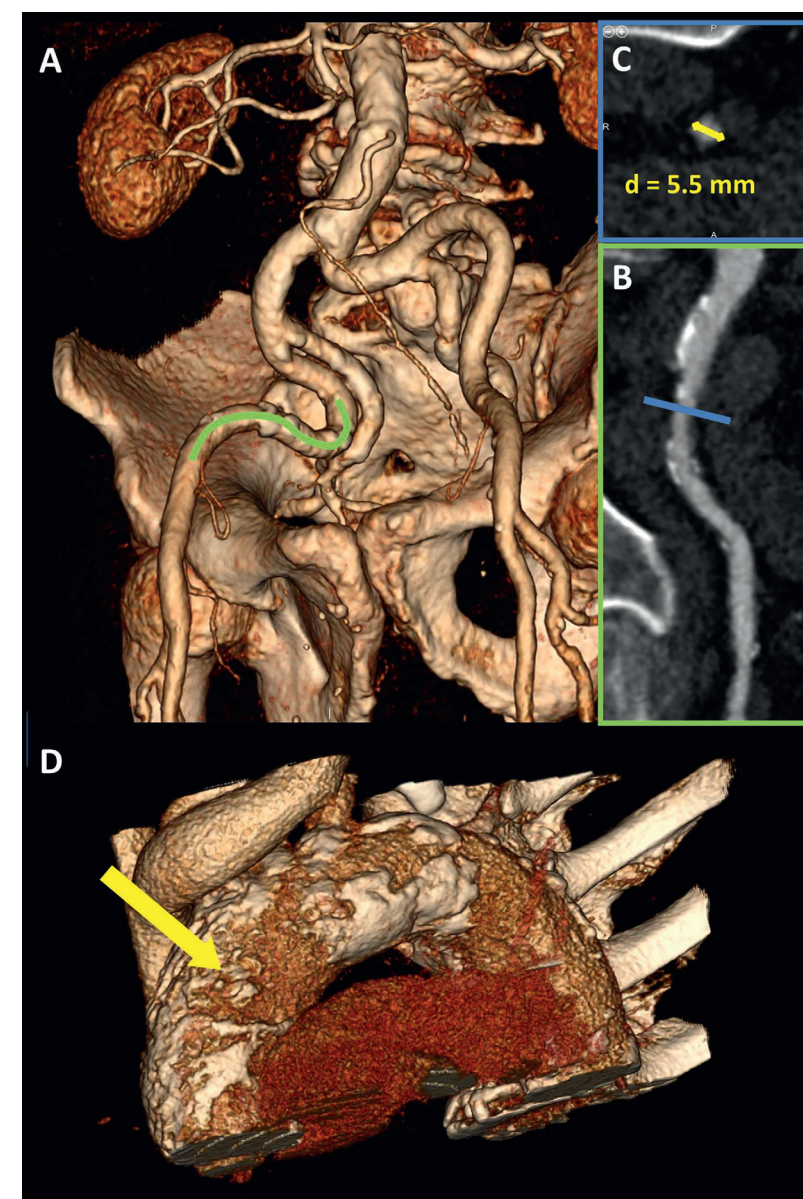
Assessment of TAVR access with multidetector row computed tomography (MDCT). (A) Severely tortuous iliofemoral arteries visualized with 3D volume rendering. (B) Segment of the right external iliac artery (green line) was more closely studied in a multiplanar reconstruction plane outlining high atherosclerotic burden with multiple plaques. (C) The cross-sectional lumen of the narrowest part of the vessel (blue line) was assessed. The smallest diameter was 5.5 mm (yellow arrow), precluding a safe transfemoral approach for the transcatheter aortic valve replacement (TAVR). (D) Severely calcified thoracic aorta – porcelain aorta particularly in the anterolateral portion of the ascending aorta, corresponding to the landing zone for transaortic approach (yellow arrow).
